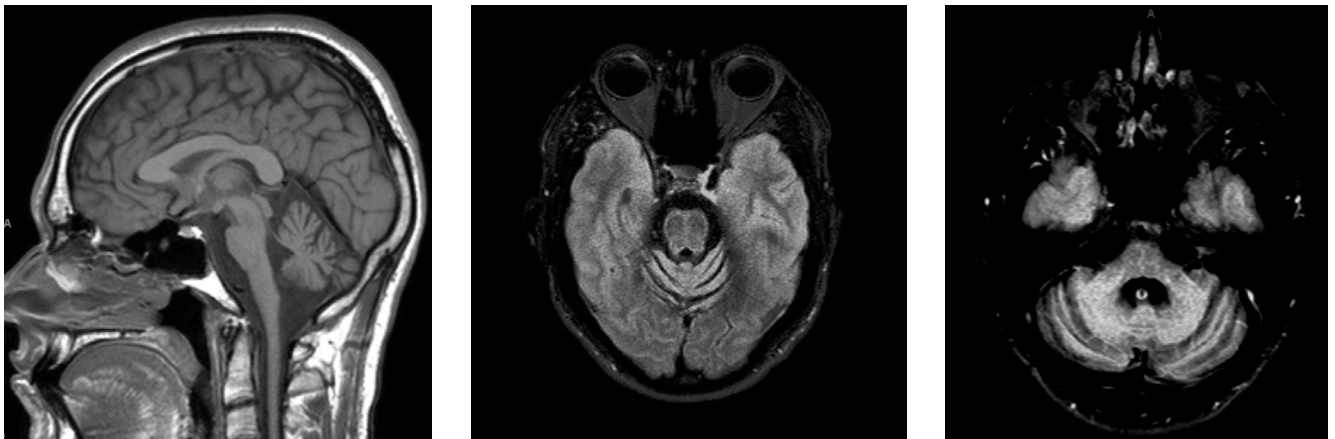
(A) Brain MRI showing severe pontocerebellar atrophy in sagittal T1-weighted imaging; (B and C) cruciform hyperintensity in the pons, the hot cross bun sign, in axial T2 FLAIR imaging reflecting selective degeneration of pontocerebellar tracts.
